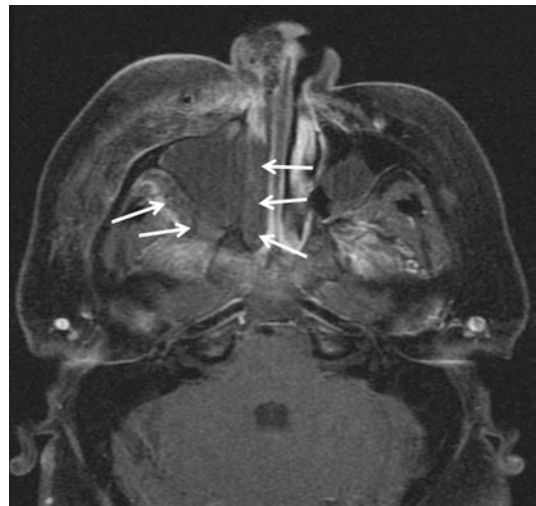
MRI of the head with contrast of the patient in Fig. 15.1. There is a large hypodense mass within the right maxillary sinus. The loss of contrast enhancement in the posterior right maxillary sinus as well as nasal cavity is highly suggestive of tissue necrosis, suggesting an angioinvasive infection
